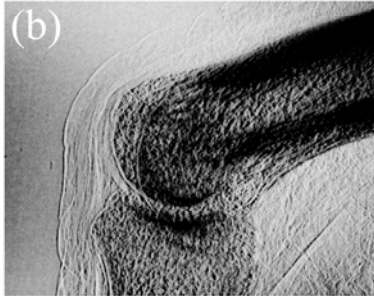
X-ray images of PIP joint with a small lesion without an intensifying screen.
